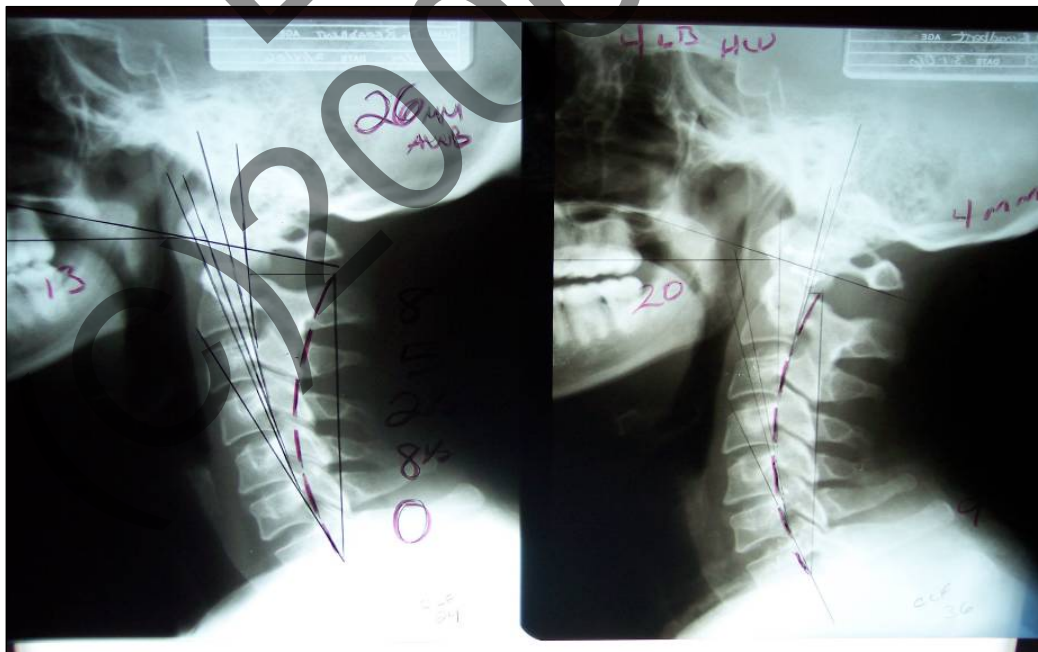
Figure 2AB. In A, a neutral Lateral cervical x-ray is shown with anterior head translation and loss of the cervical curve. In B, a weighted lateral stress view with 4 pounds showing correction.
